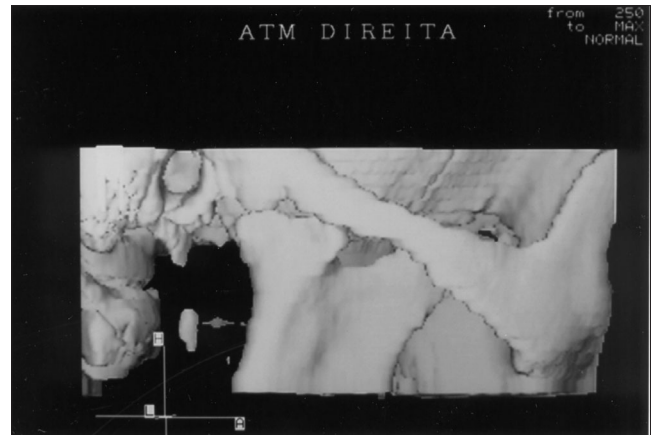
Three-dimensional reconstruction of the temporomandibular joint, based on helical computed tomography (performed at the 4-year follow-up). This image shows the affected side.
